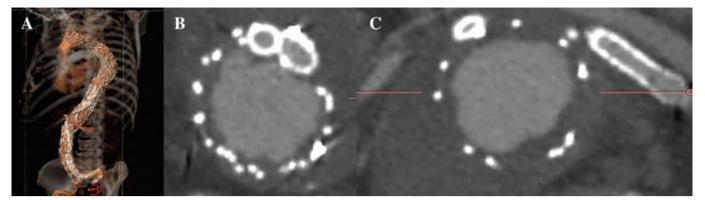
CTA at 6 (A, B) and 12 (C) months of follow-up revealed no endoleak. All stents remained patent.
